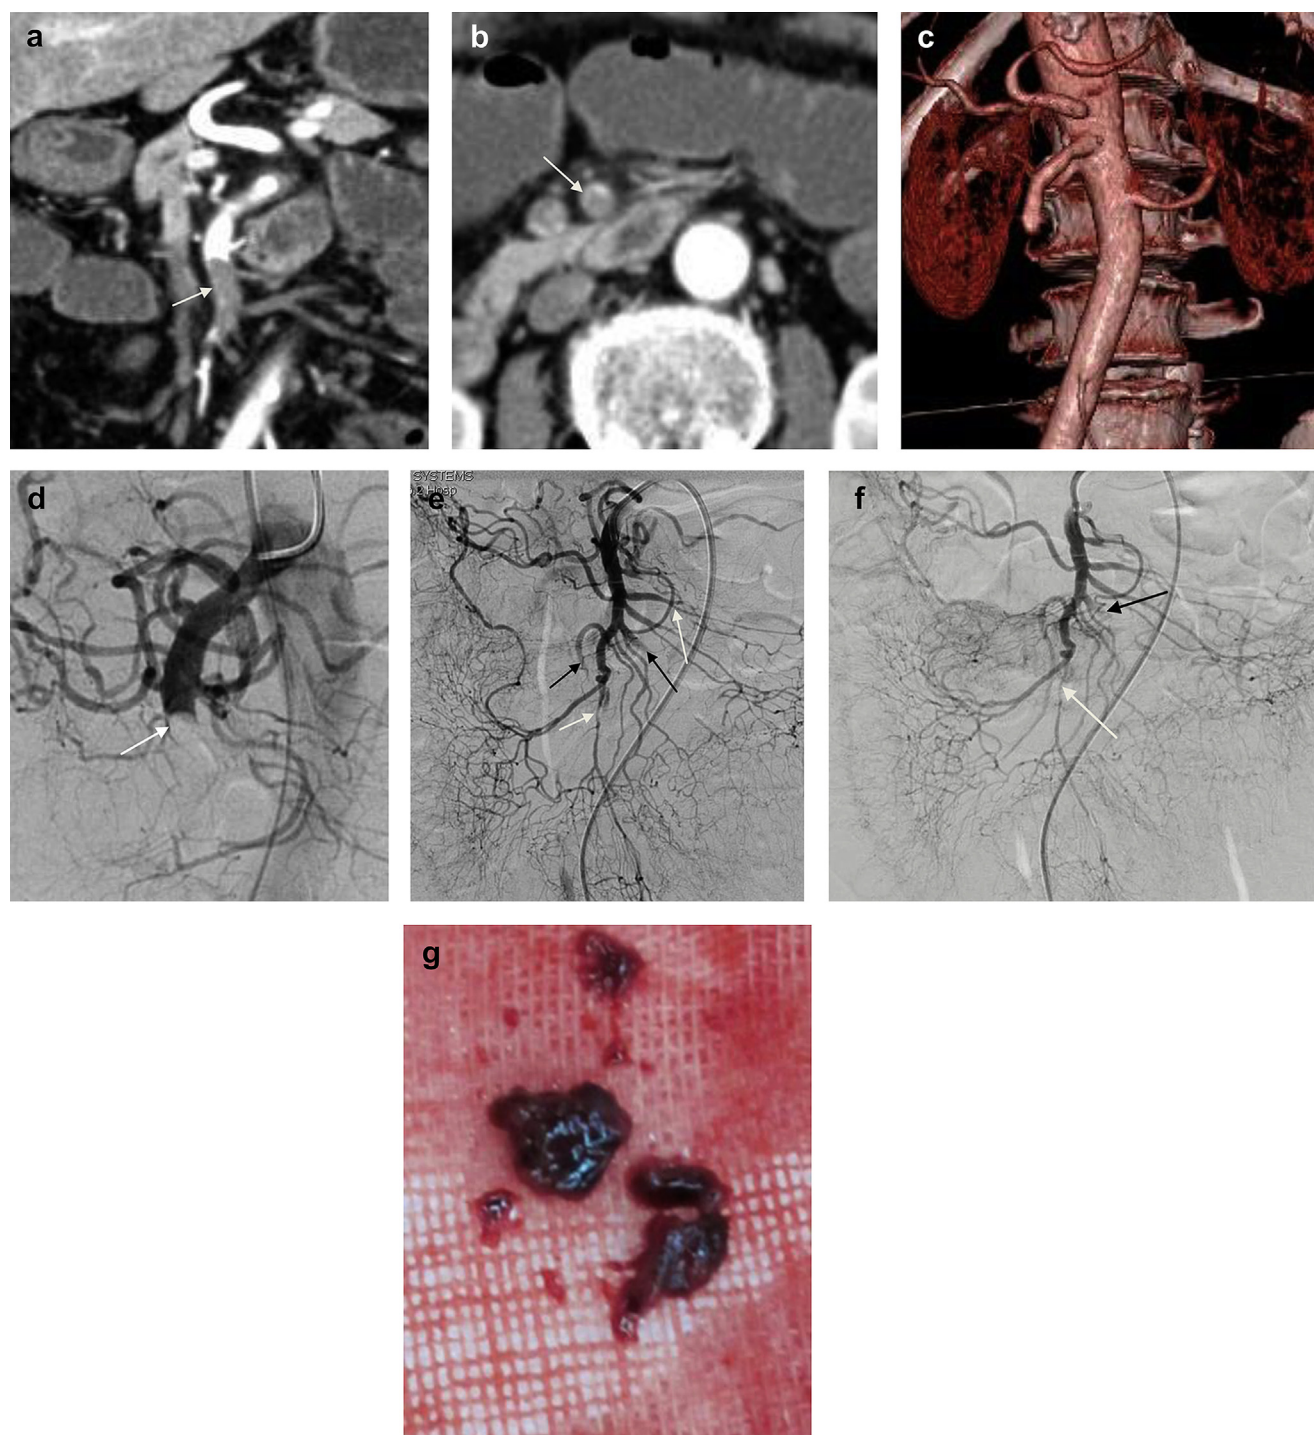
A 64-year-old man (case 11) presented with acute-onset abdominal pain that had begun 6 hours before presentation. (a) Computed tomography angiography (CTA) of the abdomen demonstrated abrupt occlusion of the superior mesenteric artery (SMA) 4.1 cm from the origin (arrow). (b) An axial image demonstrated a large central luminal filling defect with minimal contrast at the edge (arrow). (c) Volume-rendered CTA showed abrupt occlusion of the proximal SMA without collateral vessel. (d) Digital subtraction angiography (DSA) of the SMA revealed an occlusion with a convex meniscus, a typical sign for embolic occlusion (arrow). (e) After aspiration, the main trunk became patent, but small emboli (black arrows) and vasospasms (white arrows) were identified in the branches. (f) There was complete restoration of the flow to one branch (white arrow) and partial reopening to another (black arrow) after a bolus of urokinase (200,000 units) was slowly injected over 20 minutes, followed by an infusion of prostaglandin E1 (10 μ g). (g) The aspirated thromboemboli can be seen.
